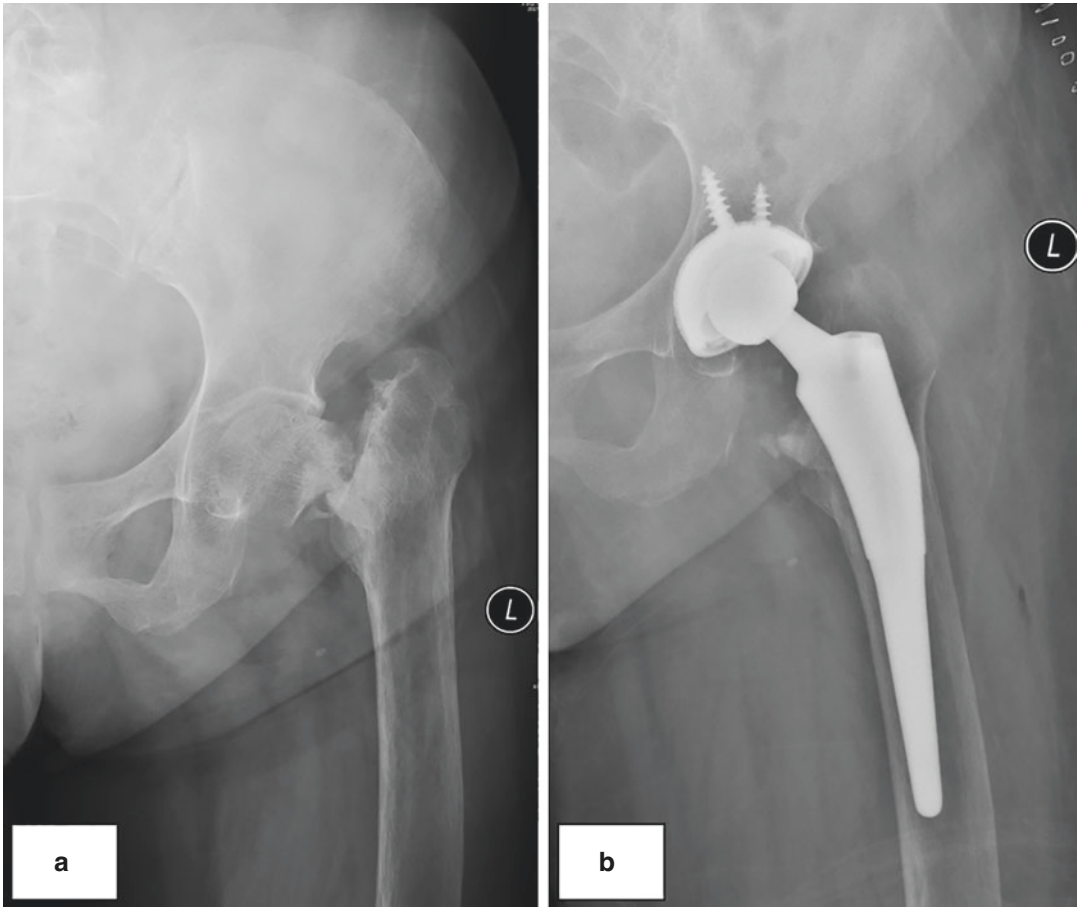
(a) A 63-year-old lady suffered from pain and disability of the left hip since untreated femoral neck fracture. The radiography showed a Dorr C-type femoral
